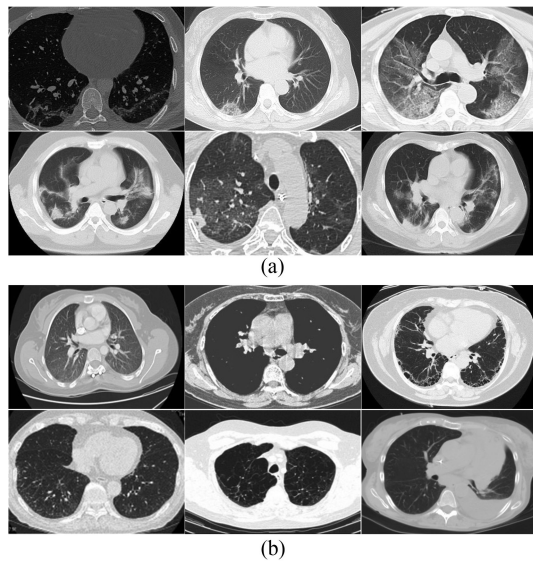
Lung CT samples in the dataset. (a) Positive COVID-19. (b) Negative COVID-19.
